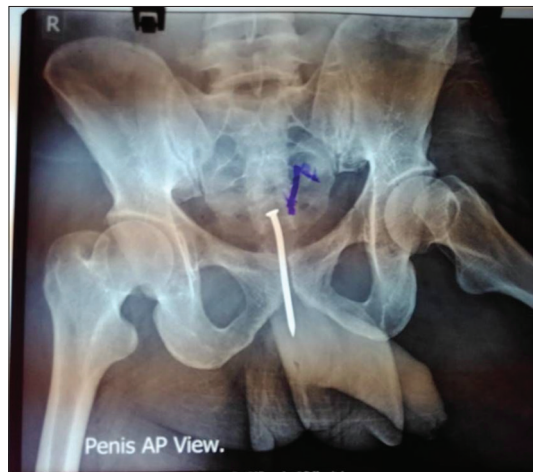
X-ray film with nail *in-situ*
